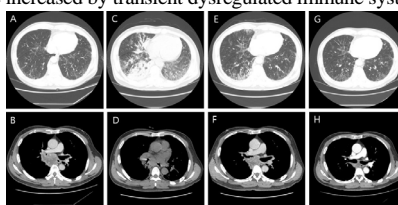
Chest Computed tomography (CT) images during the clinical course of the patient. (A and B) CT scan at diagnosis. There was no obvious abnormal shadow in the right lower lobe. (C and D) CT scan after two cycles of Atezolizumab (At the initial ER visit for pneumonia). Newly-developed consolidation with ground-glass opacity in right middle and lower lobes were found. (E and F) CT scan after 7days of intravenous antibiotics administration. Markedly decreased ground glass opacity in the right middle and lower lobes was found with overall decreased extent of tumor - 41.4% decreased from baseline. (G and H) CT scan after four cycles of Atezolizumab. Overall decreased extent of tumor - 60.9% decreased from baseline was found. The consolidation with ground-glass opacity in right middle and lower lobes were completely disappeared at this point.
